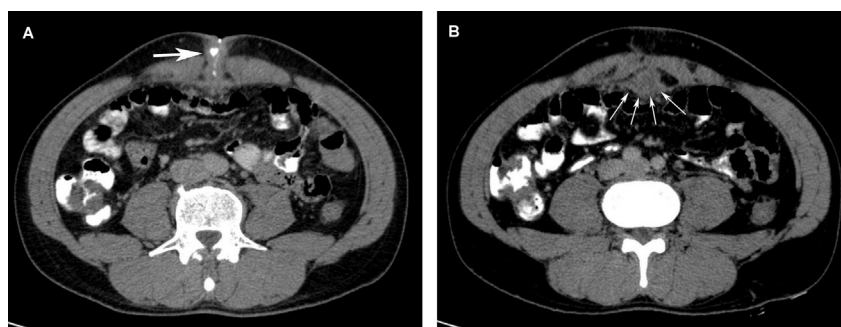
Axial intravenous contrast enhanced CT sections with umbilical instillation of contrast (A) reveal peripherally enhancing hypodense collection (B).
